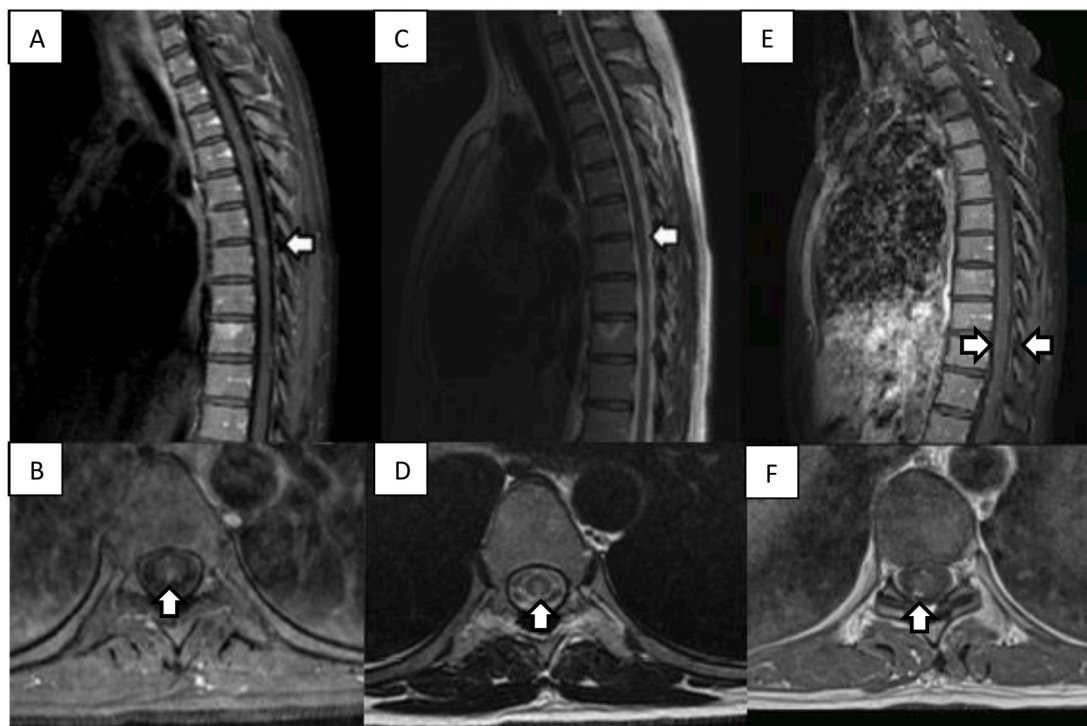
A: T1 Post-Gadolinium MRI of the dorsal spine in sagittal view showing a patchy enhancement (white arrow). B: Post-Gadolinium axial T1 showing patchy enhancement. C: T2-weighted MRI of the T5-T6 lesion (white arrow). D: Axial T2-weighted MRI showing a dorsal position of the lesion. E: 5 months sagittal T1-post-gadolinium MRI showing a linear meningeal enhancement. F: 5 months MRI with post-Gadolinium axial T1 showing patchy meningeal enhancement.
